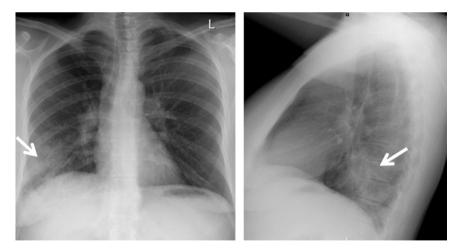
Right lower lobe pneumonia on PA and lateral chest radiograph. Note the asymmetric patchy increased density in the right lateral lower lung on the PA image. On the lateral view there is abnormal increased opacification overlying the lower thoracic vertebrae, which usually appear darker than upper thoracic vertebral bodies on a normal lateral radiograph, this is known as the Spine Sign
